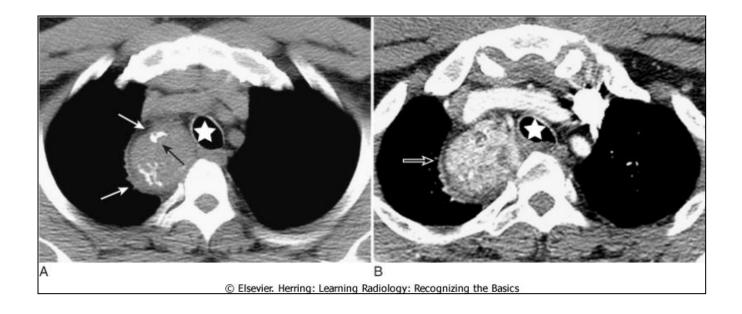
CT of a substernal thyroid goiter without and with contrast enhancement. These two images were taken at the same level in a patient who was scanned both before (A) and then after intravenous contrast administration (B). On CT scans, substernal thyroid masses (closed white arrows in A) are contiguous with the thyroid gland, frequently contain calcification (closed black arrow) and avidly take up intravenous contrast but with a mottled, inhomogeneous appearance (open white arrow in B). This mass is displacing the trachea (white stars) slightly to the left.
